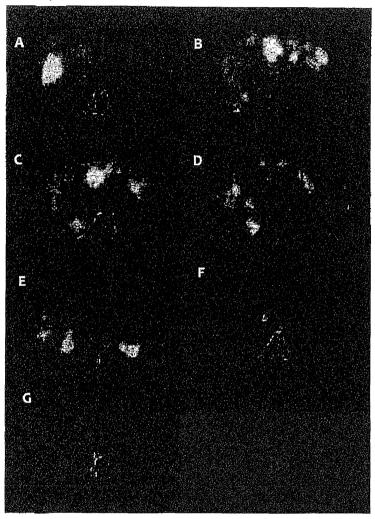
PET-CT PET-CT showed multiple abnormal accumulation of fluorodeoxyglucose in the liver (A, B, C, D and E), hilar lymph node (F) and mediastinal lymph node (G).
